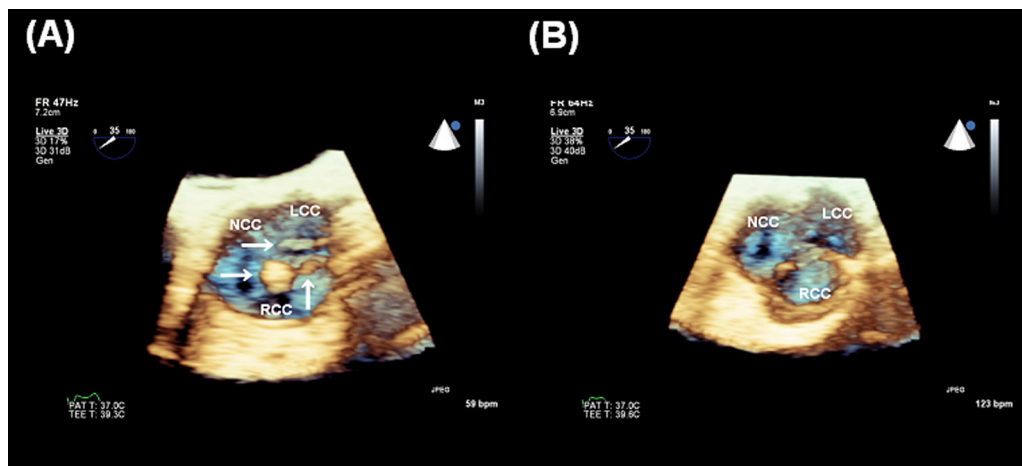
(A) Aortic valve image by three dimensional zoom transesophageal echocardiography (TEE) showing three masses attached to the non- and right coronary cusp and of the aortic valve (arrow). (B) Aortic valve image by three dimensional zoom TEE after removal of papillary fibroelastoma. RCC, right coronary cusp; LCC, left coronary cusp; NCC, non-coronary cusp.
